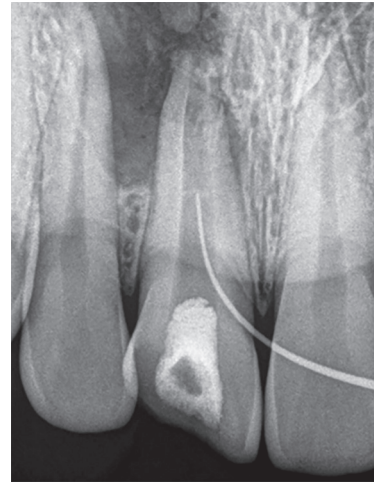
Preoperative periapical radiograph revealed large well-defined periapical radiolucency in relation to 11 and 12. Gutta-percha tracing through sinus revealed the lesion mainly extended around 11
